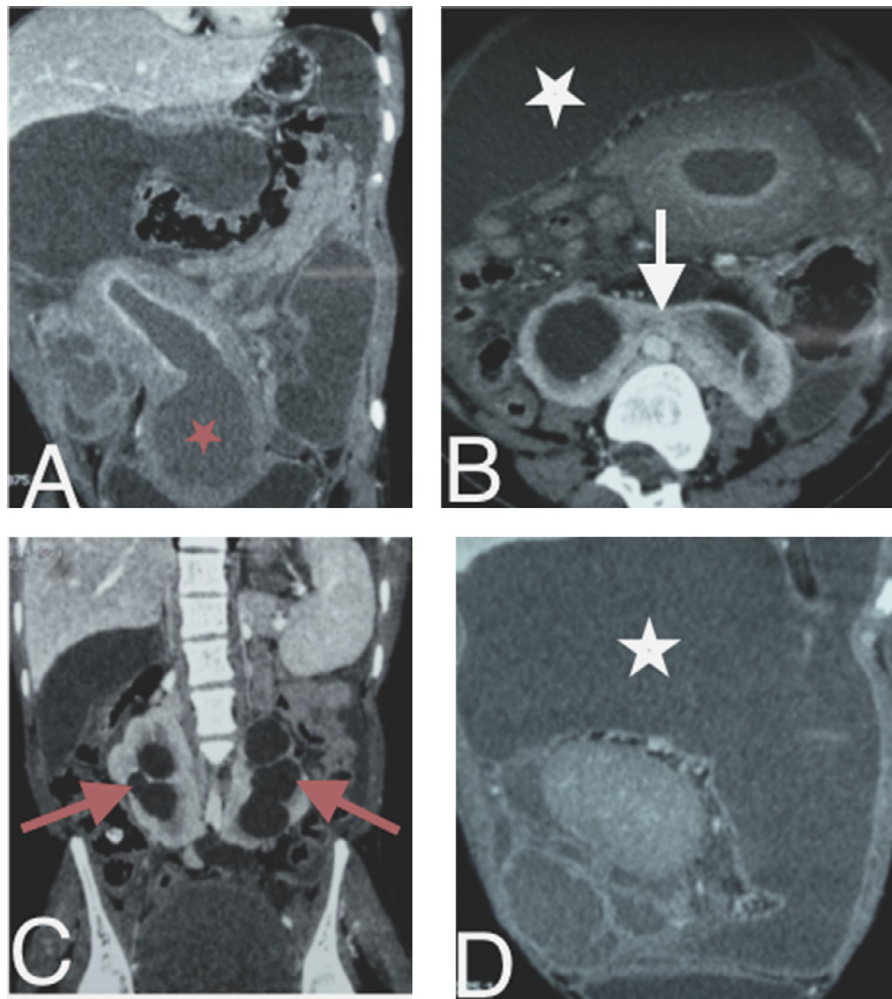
Abdominal CT scan with contrast. (A) Coronal view showing dense collection dilating uterine and vaginal cavities (red star). (B) Axial view showing the anterior loculated peritoneal collection (white star) and the horseshoe kidneys, joined by a median tissue band (white arrow). (C) Coronal view showing renal cavity dilation (red arrows) causing bilateral hydronephrosis. (D) Coronal view showing the dense peritoneal collection (white star).
